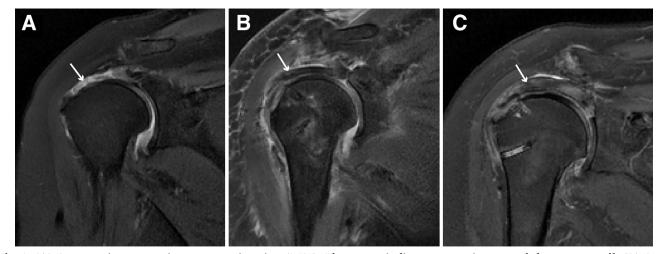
(A) Preoperative magnetic resonance imaging (MRI). The arrow indicates a massive tear of the rotator cuff. (B) Postoperative MRI at 3 days. The arrow indicates the sandwich patch graft. (C) Postoperative MRI at 6 months. The arrow indicates the sandwich patch graft.
